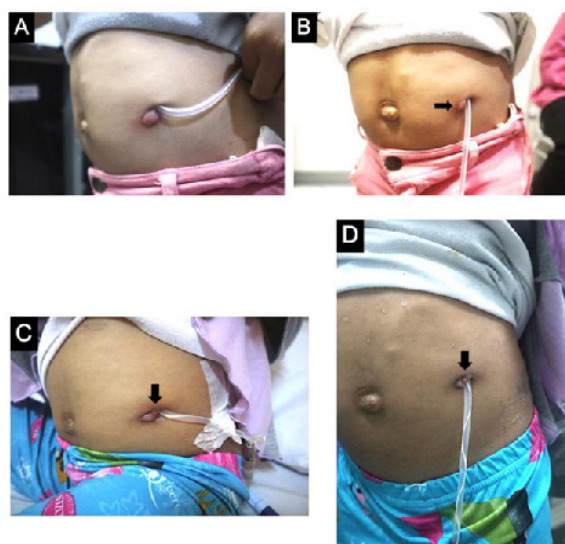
Twisted peritoneal dialysis catheter. A, Exit-site score was 4 (no swelling, crust < 0.5 cm, redness 1 cm, slight pain, no secretions) with gaping, on admission. B, Erythematous swelling (1.5 cm) indicating a chronic irritant contact dermatitis lesion due to the peritoneal dialysis catheter tube (black arrow). The friction occurred because the patient's caregiver did not perform daily catheter fixation with tape due to reports of discomfort to the patient. C, On the third day of hospitalization, the peritoneal dialysis external catheter was twisted. Granuloma was visible (black arrow). D, The twisted peritoneal dialysis catheter was more prominent on the seventh day of hospitalization. Granuloma remained visible (black arrow). E, Abdominal radiographs demonstrating catheter tip in the pelvic area while the patient was undergoing peritonitis treatment. F, Subcutaneous cuff located 2.4 cm from the exit-site G, Exit-site showing improvement after 2 weeks of treatment.
